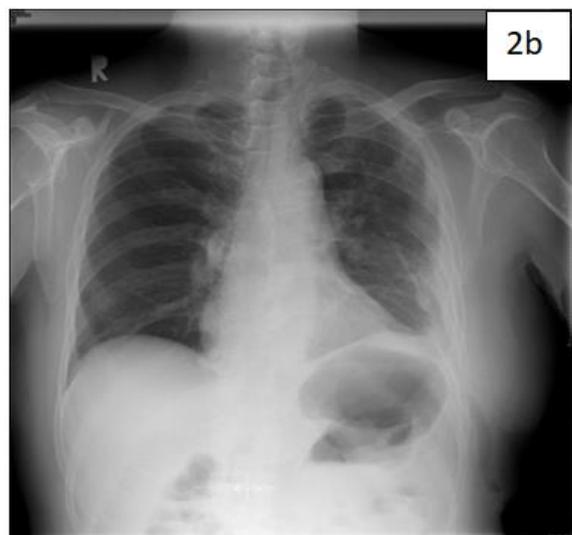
Post operative chest x-ray, showing good lung expansion with residual opacification on the chest x-ray
